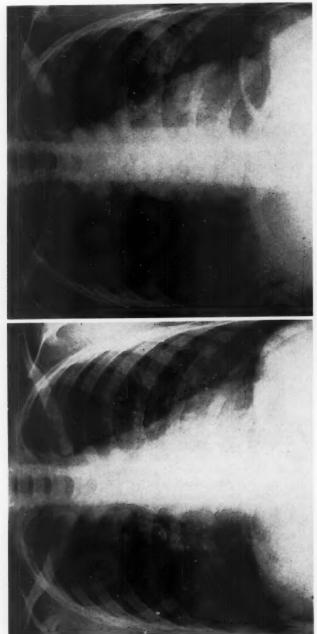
(left). Discharge chest x-ray, two months after first admission, shows residual hilar and mediastinal adenopathy. Residual fine reticular pulmonary fibrosis is present.
